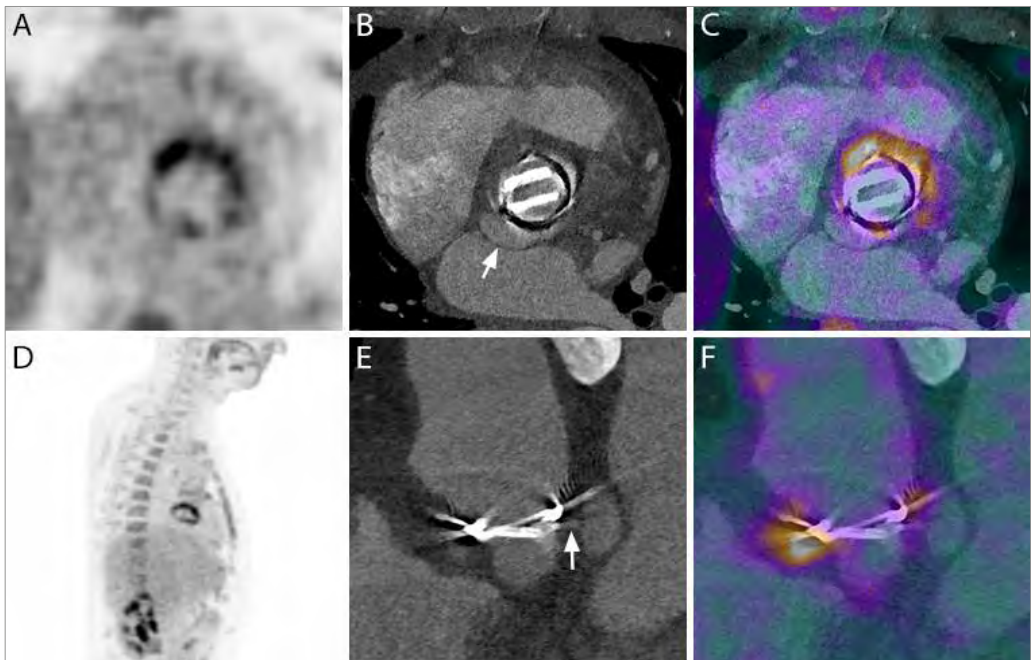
PET (A, D), CTA (B, E) and fused PET/CTA (C, F) images of a patient with a combined aortic valve and ascending aortic prosthesis following a Bentall procedure for *Staphylococcus aureus* endocarditis, who was diagnosed with recurrent endocarditis, this time of *Streptococcal* origin. CTA showed a pseudo-aneurysm on the posterior side of the aortic prosthetic valve that was however PET-negative, and therefore most likely a remainder of the previous episode of endocarditis (CTA had not been performed after the Bentall procedure). The patient was reoperated upon and the perivalvular extension, which was surgically corrected, did not show any signs of active infection according to the cardiothoracic surgeon.
